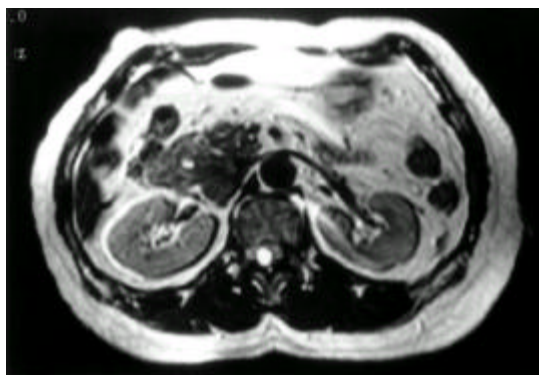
Abdomen MRI shows the IVC mass of intermediate signal intensity in T1WI.
